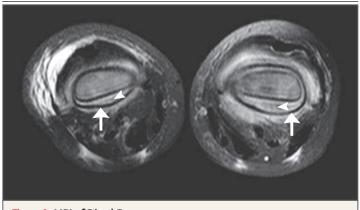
MRI of Distal Femurs.
